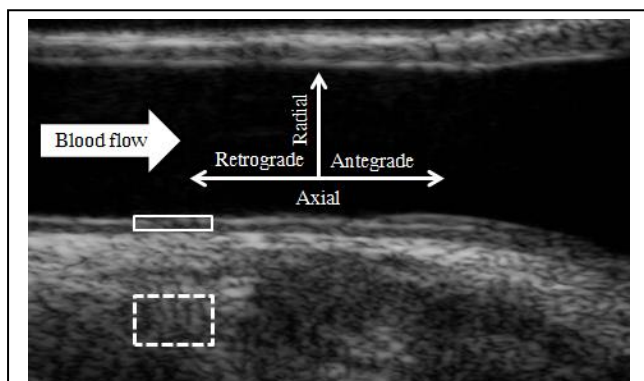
B-mode ultrasound image of a common carotid artery. Retrograde and antegrade directions have been marked on the axial plane. Solid rectangle displays the region of interest (ROI) used in the motion tracking of intima-media and dashed rectangle displays the ROI used as a reference point for the motion estimation.
